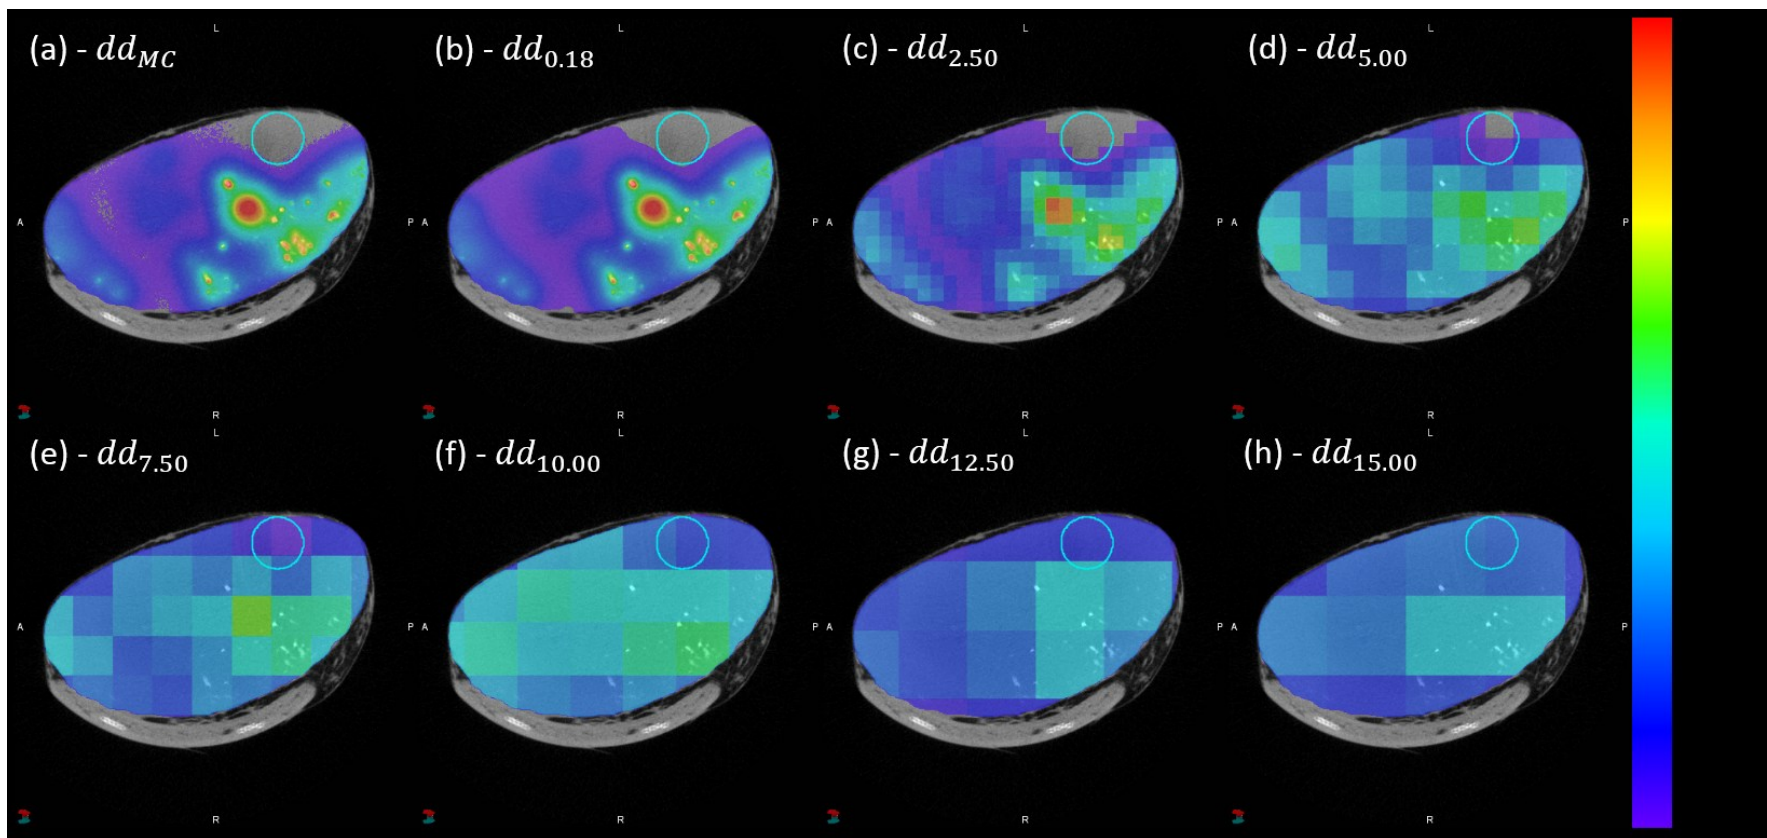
Axial fusion of μ CT and dose distributions containing planar contours of the normal tissue (Cyan) [HU: 0 to 1500]. (a) dd_{MC} (b) $dd_{0.18}$ (c) $dd_{2.50}$ (d) $dd_{5.00}$ (e) $dd_{7.50}$ (f) $dd_{10.00}$ (g) $dd_{12.50}$ (h) $dd_{15.00}$.
